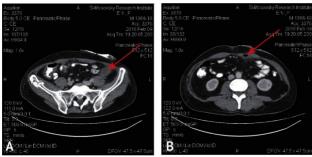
A 42-year-old male patient F. The CT scan on day 37 after trauma. The localized fluid accumulation of 18 cm³ (initially 95 cm³) was revealed in the anterior abdominal wall in the projection of the left iliac region (A). A nonuniform area due to gas inclusions was revealed in the muscles of the anterior abdominal wall, which didn't accumulate a contrast agent. The fiber adjacent to this area was infiltrated (B)
